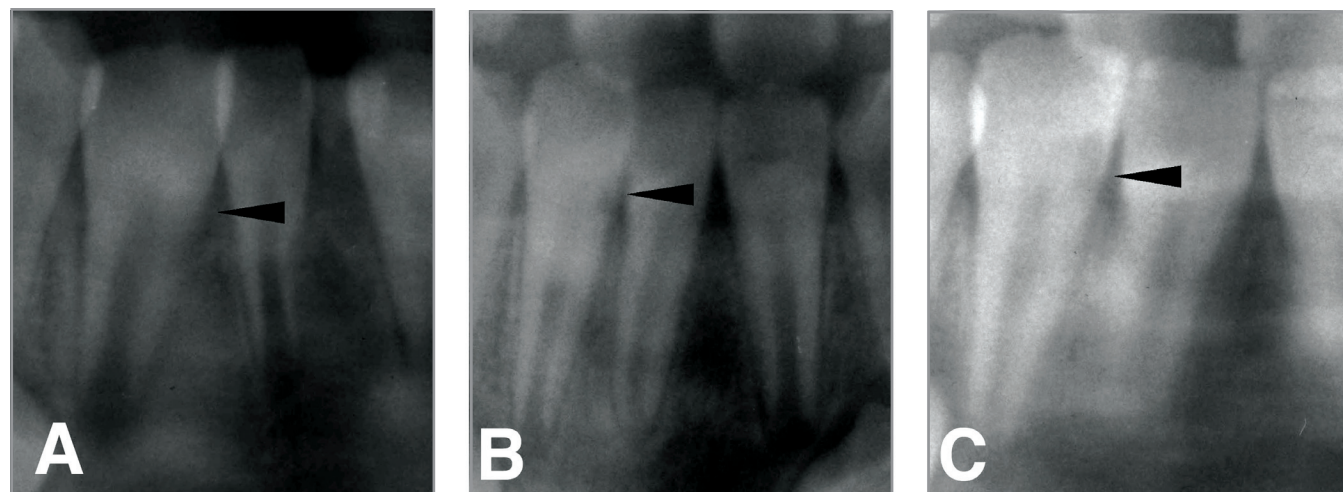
Details of panoramic radiographs showing the development of the lesion of the permanent mandibular right lateral incisor. (a) Panoramic radiograph at age 8.5 years showing no clear lesion. (b) Panoramic radiograph at age 9 years 3 months showing suspicious radiolucency (arrow). (c) Panoramic radiograph at age 10 years 1 month showing small radiolucency (arrow).
